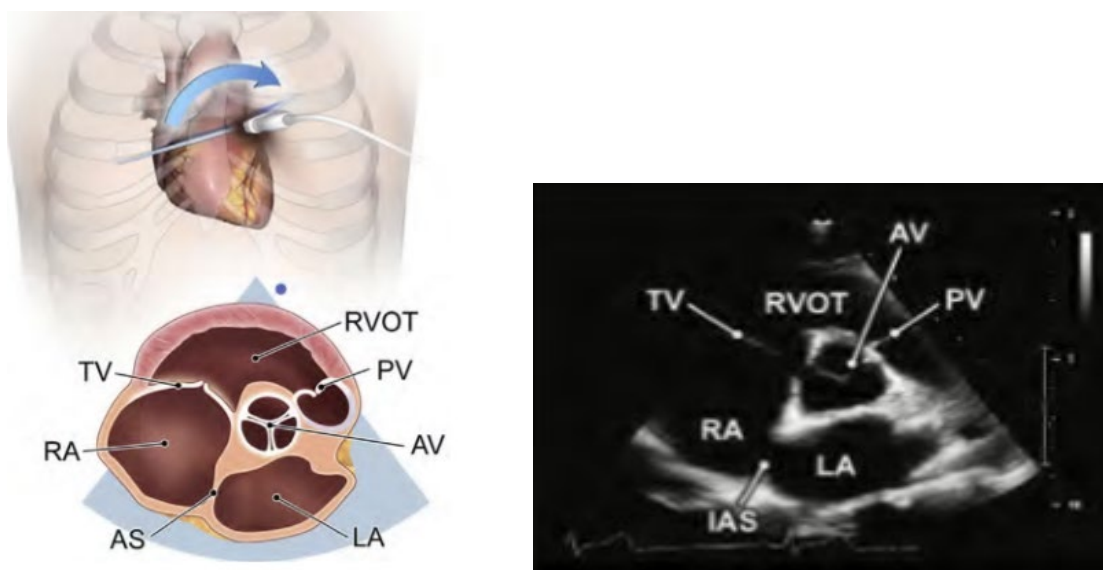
Parasternal short axis view. Reproduced with permission from the American Society of Echocardiography. (135)
